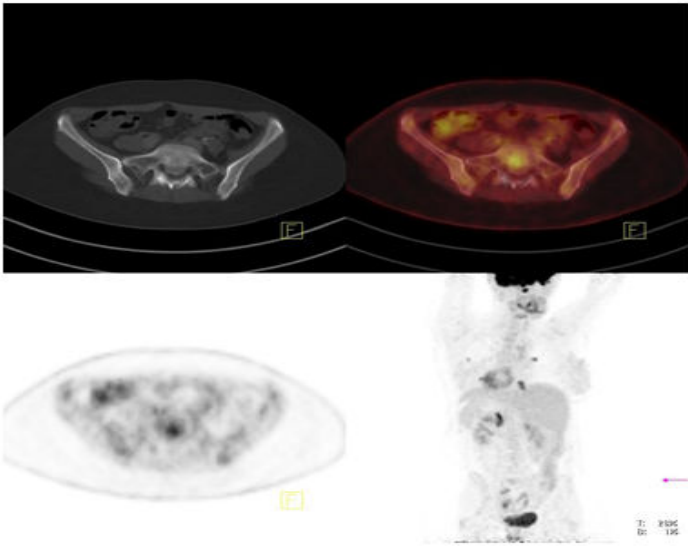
The detection of bone metastasis in PET/CT.
